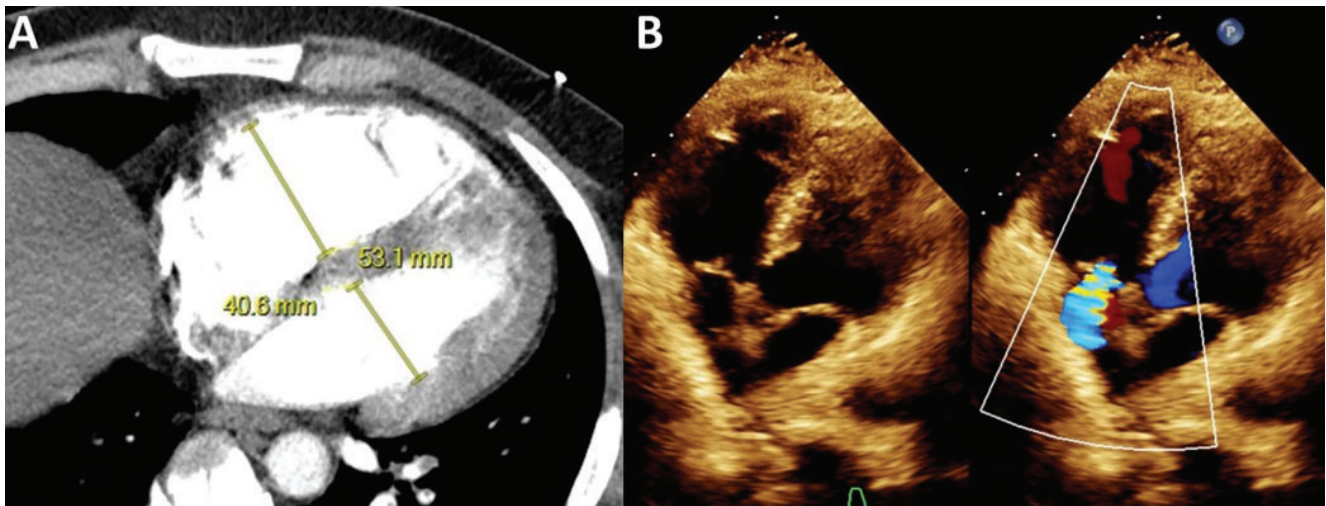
(A) Computed tomography and (B) echocardiogram showing an increased right ventricle-to-left ventricle ratio, which is used to assess right ventricular strain and dysfunction for risk stratification of pulmonary embolism.
